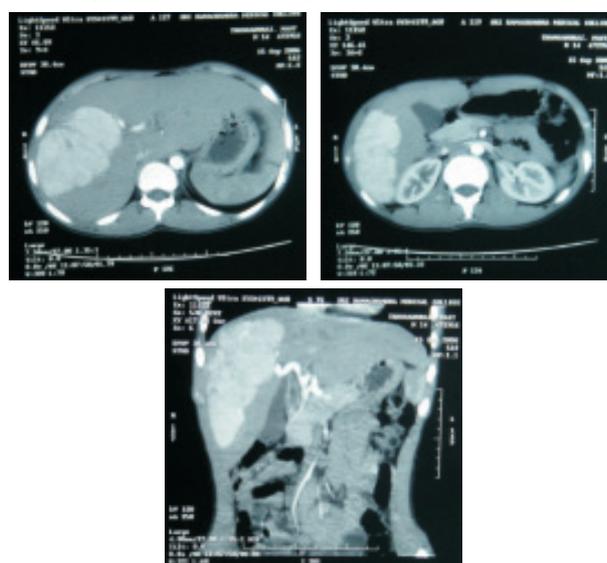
Arterial phase of CT demonstrating the brisk and uniform enhancement of the entire lesion
